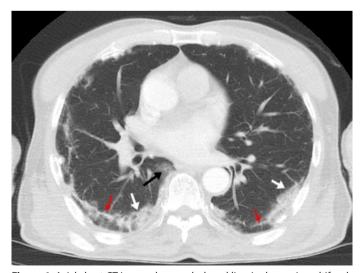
Axial chest CT image shows subpleural line (red arrow), multifocalperipheral ground-glass opacities (black arrow), and consolidation (white arrow)-typical appearance for SARS-COV-2.
